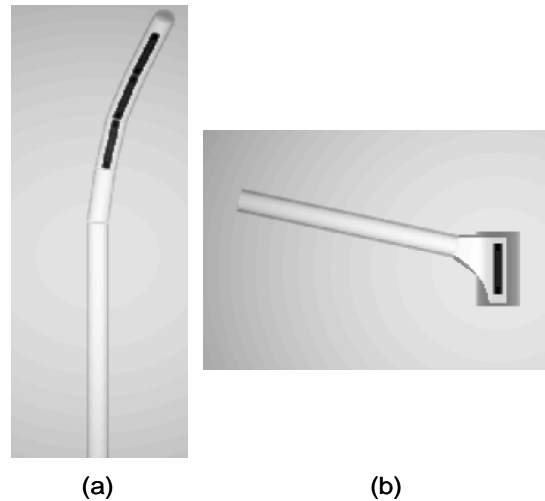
CBCT projection images obtained from the PTRAN Monte Carlo ray-tracing routine, (a) central intrauterine tandem (with 42.44° curvature), and (b) left colpostat model, where the grayscale image background represent uniform elliptical water cylinder. The black line segments in the tandem clearly show the stepping source position at different dwell time. The line source position is also shown in the left colpostat. The image intensity values represent an arbitrary integer number assigned to each material component in the model (paper III).
